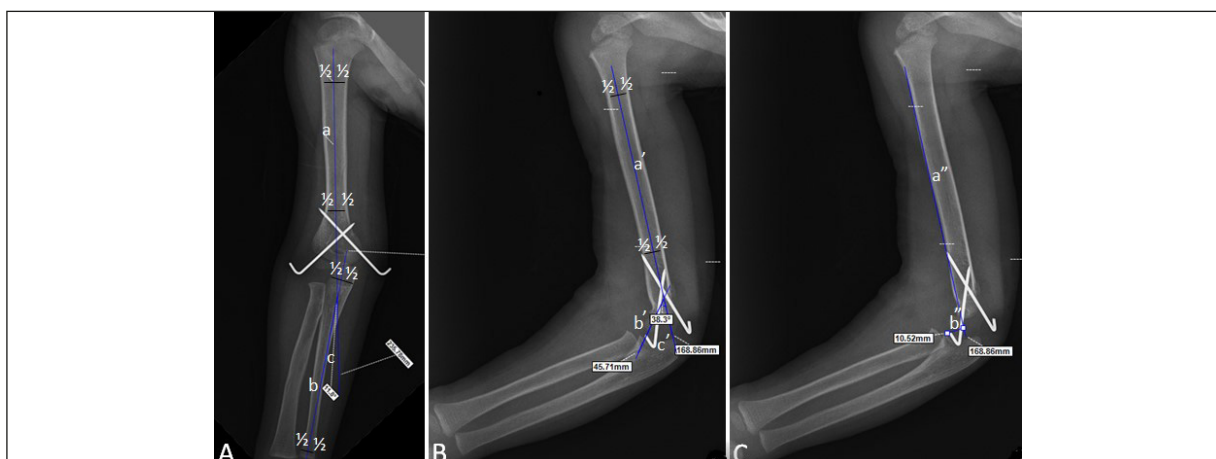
Radiographic of measurement. A, Humeral ulnar angle (a: humeral shaft line; b: ulnar shaft line; c: humeral ulnar angle). B, Humeral condyle angle (a': humeral shaft line; b': axis of the distal humeral condyle; c': humeral condyle angle). C, Distance between the coronoid and anterior humeral line (a'': anterior humeral line; b'': distance between the coronoid and anterior humeral line).
